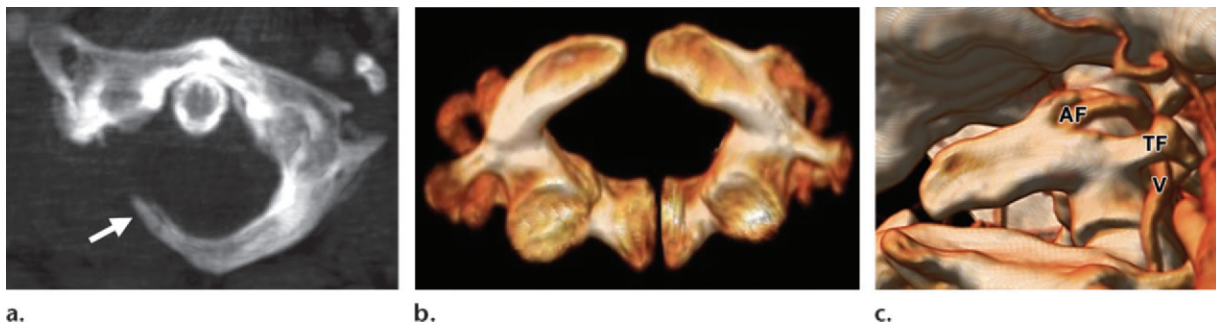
Congenital anomalies in a 50-year-old man with a type II dens fracture after a bodysurfing accident. (a) Axial MIP image of the atlas shows a congenital defect involving a portion of the right posterior arch. The tip of the developed portion of the right posterior arch is fractured (arrow). (b) Volume-rendered CT image of the atlas with anterior and posterior congenital clefts. The atlas has been virtually disarticulated by using the mask function. (c) Volume-rendered CT image of the atlas shows the vertebral artery (*V*) coursing through the right transverse foramen (*TF*) and entering a right arcuate foramen (*AF*).
